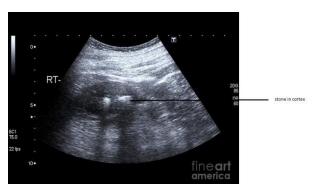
1.2 Ultrasound Image showing renal stone
